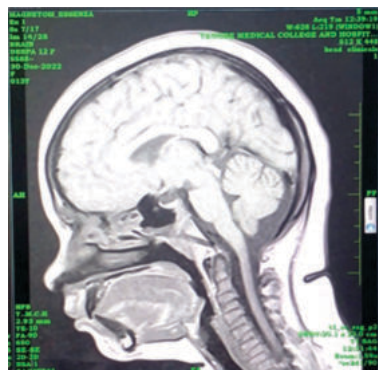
MRI Brain Of The Patient
